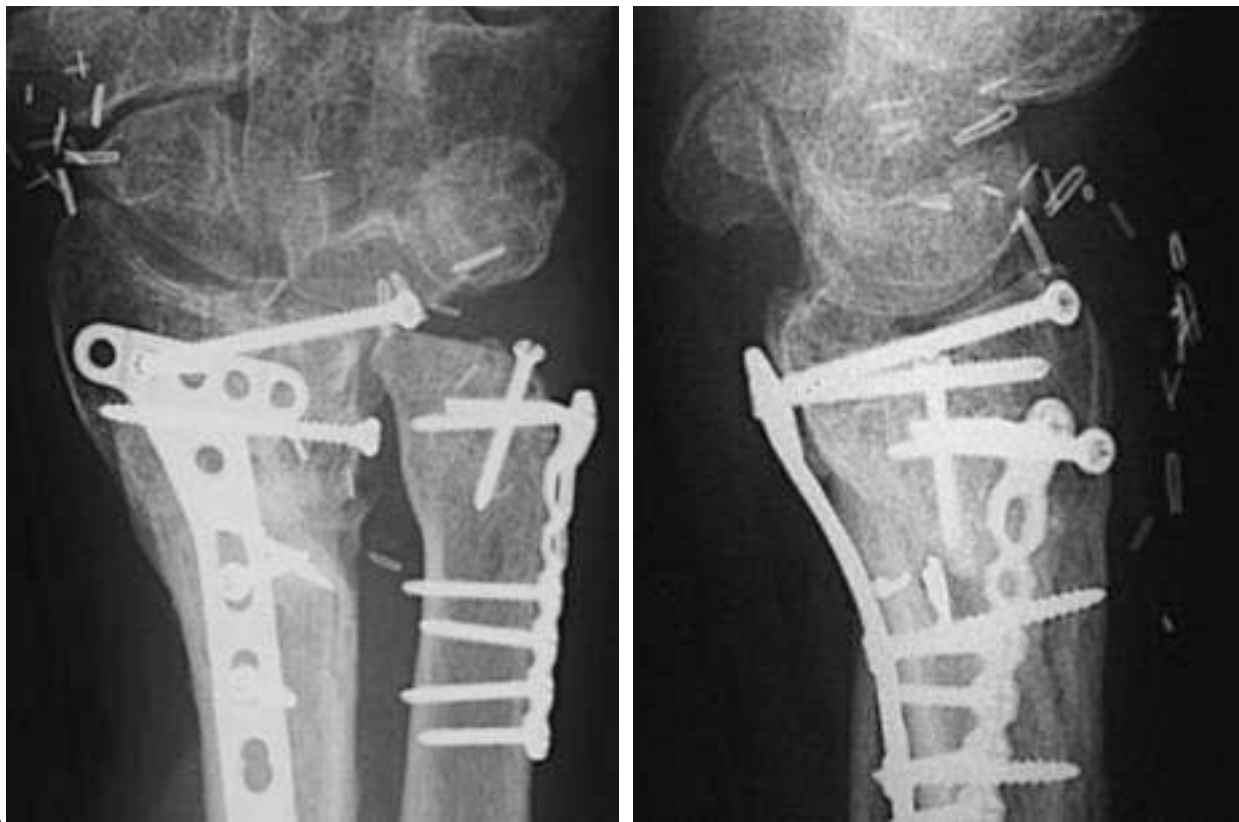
(A and B) Posteroanterior and lateral x-rays of case N°2 after a period of 8 months. Graft is fixed with two posteroulnar screws (the rest of the material corresponds to the first surgery). The ulna was shortened concomitantly to the transplant in the median third of the diaphysis (not shown in x-ray).
